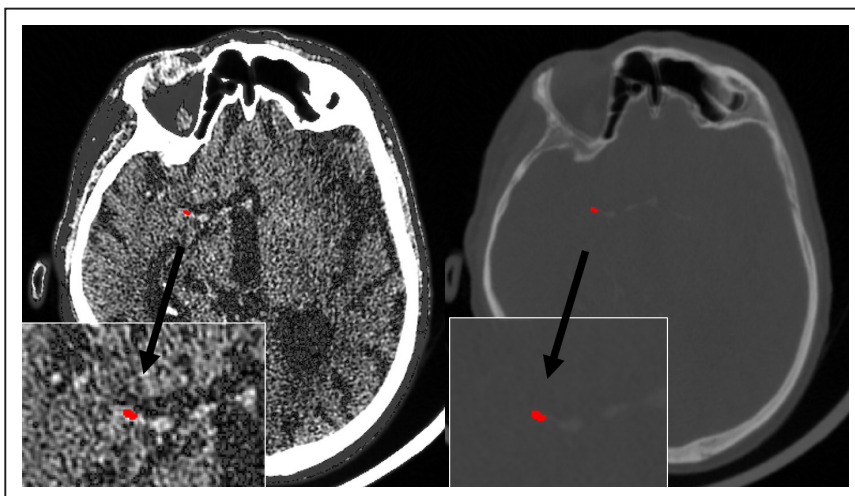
Example of measurements of thrombus density in automatically aligned noncontrast computed tomography (left, mean Hounsfield units [HU]=64.7) and computed tomographic angiography images (right, mean HU=92.0) of a patient with acute M1 vessel occlusion with known atrial fibrillation.
